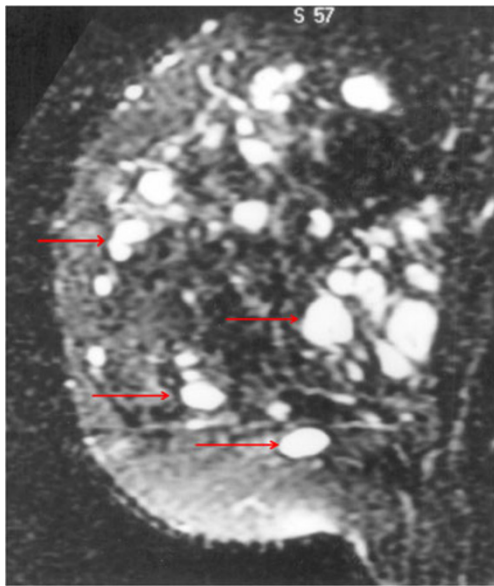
Female patient with CNC and breast myxomatosis. MR image: sagittal, fat suppressed fast spin echo T2-weighted image demonstrates numerous hyperintense nodules corresponding to myxoid fibroadenomas (red arrows)
